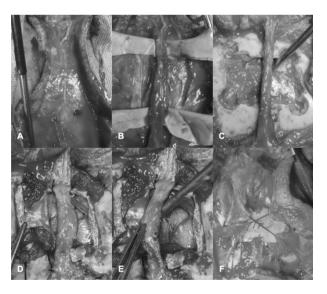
Revascularization by EDAMS. A-B: a linear incision is made along the course of the STA (dashes) with the aid of Doppler U/S and the artery is dissected and mobilized. C-D: a 5x5 cm craniotomy is created underlying the STA, and the dura opened and reflected in a cruciate fashion, with special care to preserve the middle meningeal artery. E: the STA and strips of temporalis muscle are sutured to the cortical surface adjacent to cortical MCA branches (star). F: reimplantation of the bone
